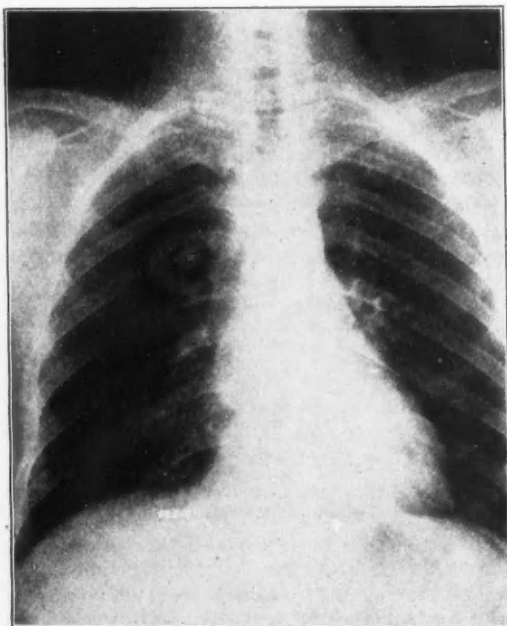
Patient represented in Figure 3 one month later and three weeks after a course of roentgen irradiation. Marked reduction in the size of the mediastinal tumor is shown.
